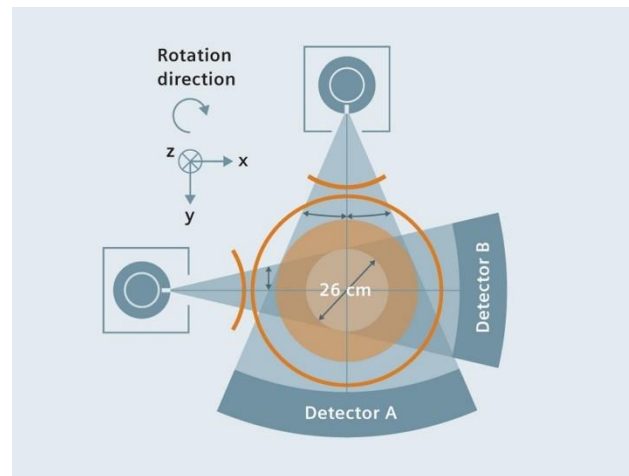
Dual-energy CT scan (courtesy Siemens).
